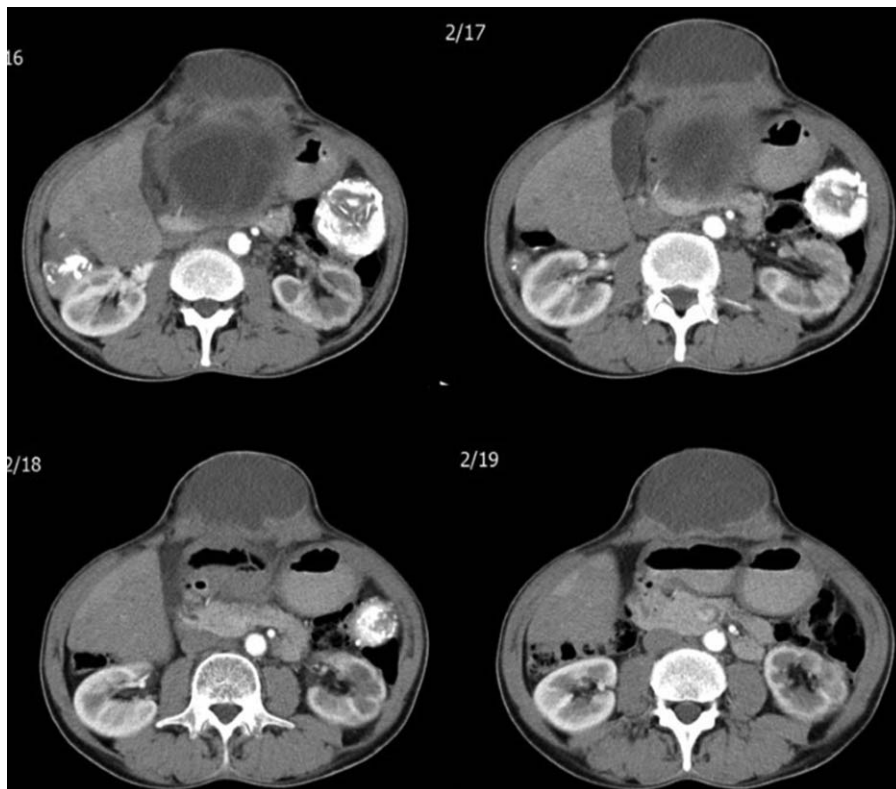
Sequential abdominal computed tomography images taken after injecting contrast material. A lesion consistent with a hydatid cyst is seen starting from segment 3 of the left liver lobe and protruding into the anterior abdominal wall.
